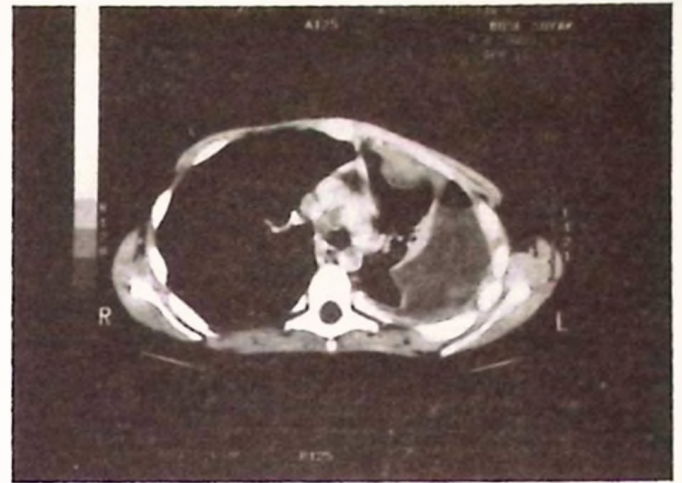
Post-surgical computed tomography scan demonstrates a new pleural based solid mass of 2 cm in anterior chest wall accompanying the pleural effusion in the left hemithorax.
